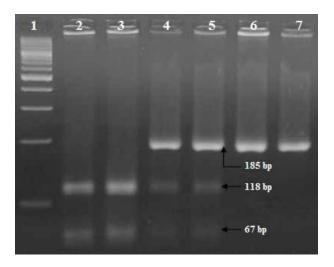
Electrophoretic analysis after BtgI digestion Lane 1 = DNA marker (GeneRulerTM 100 bp Plus, MBI Fermentas), lanes 2, 3 = $MSTN/BtgI^{CC}$, lanes 4, 5 = $MSTN/BtgI^{CT}$, lanes 6, 7 = $MSTN/BtgI^{TT}$
